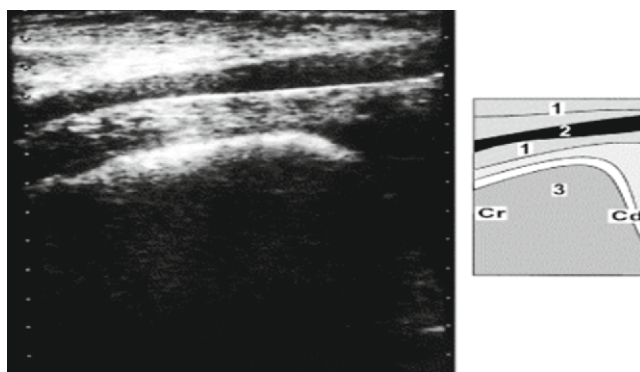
Ultrasound exam of the normal reticulum viewed from the left ventral thorax: (1) ventral abdominal wall, (2) musculophrenic vein, (3) reticulum. Cr: cranial and Cd: caudal (Braun, 2003).
